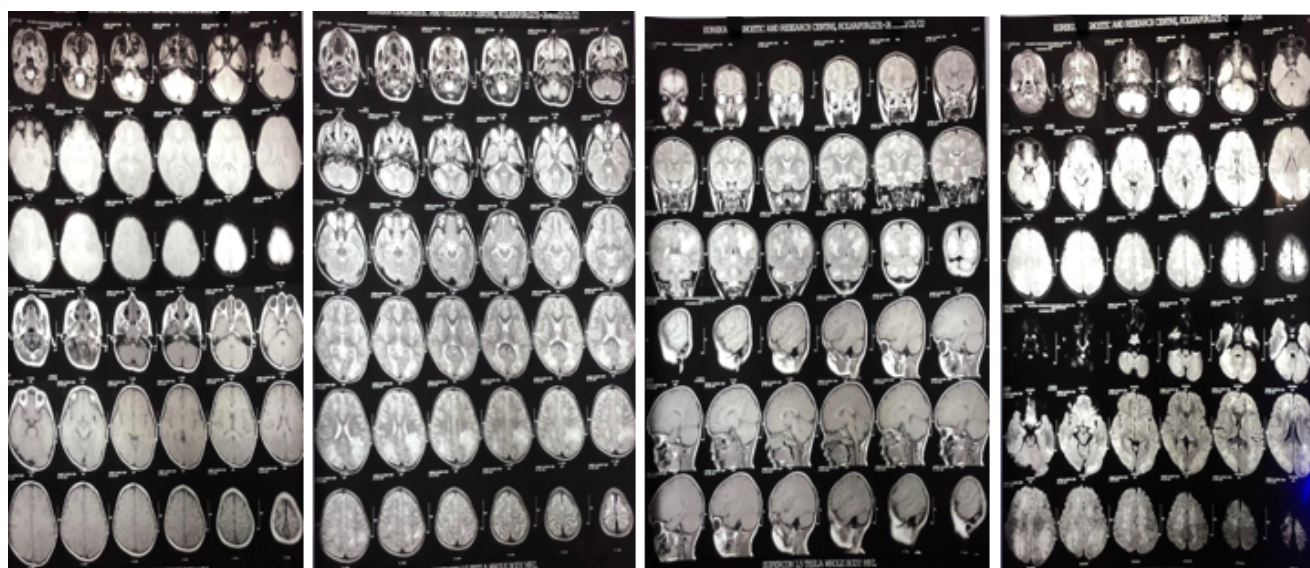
MRI Images of patient suggestive of genetic leukodystrophy.
